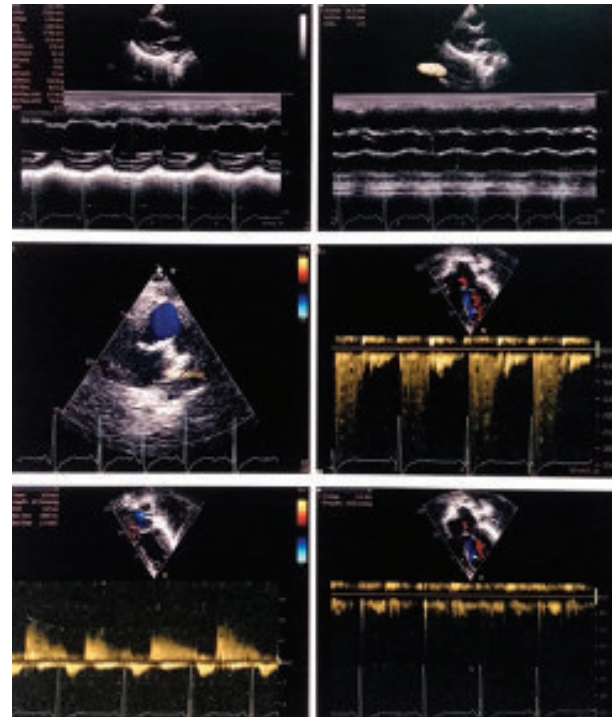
Echocardiography after treatment of PPCM showing EF-62%
